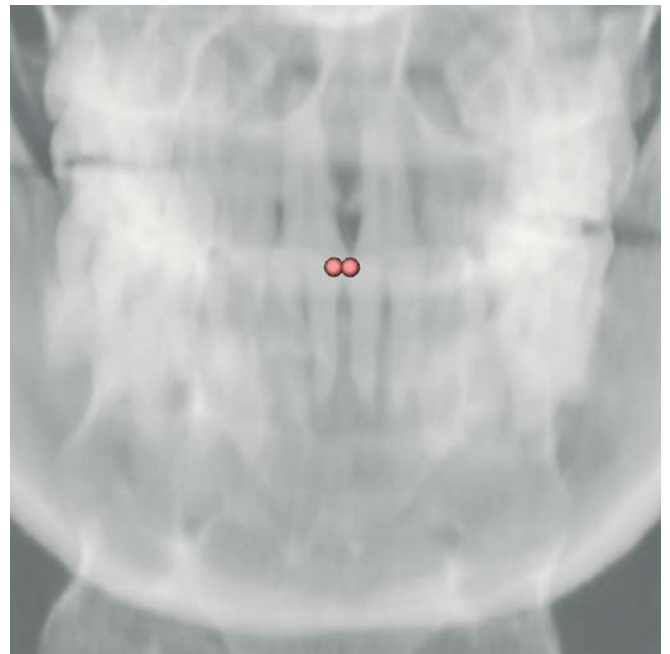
Lower Incisor (LI_r – LI_l) landmarks. Virtual frontal cephalogram (3-D CT, patient K.C.)
